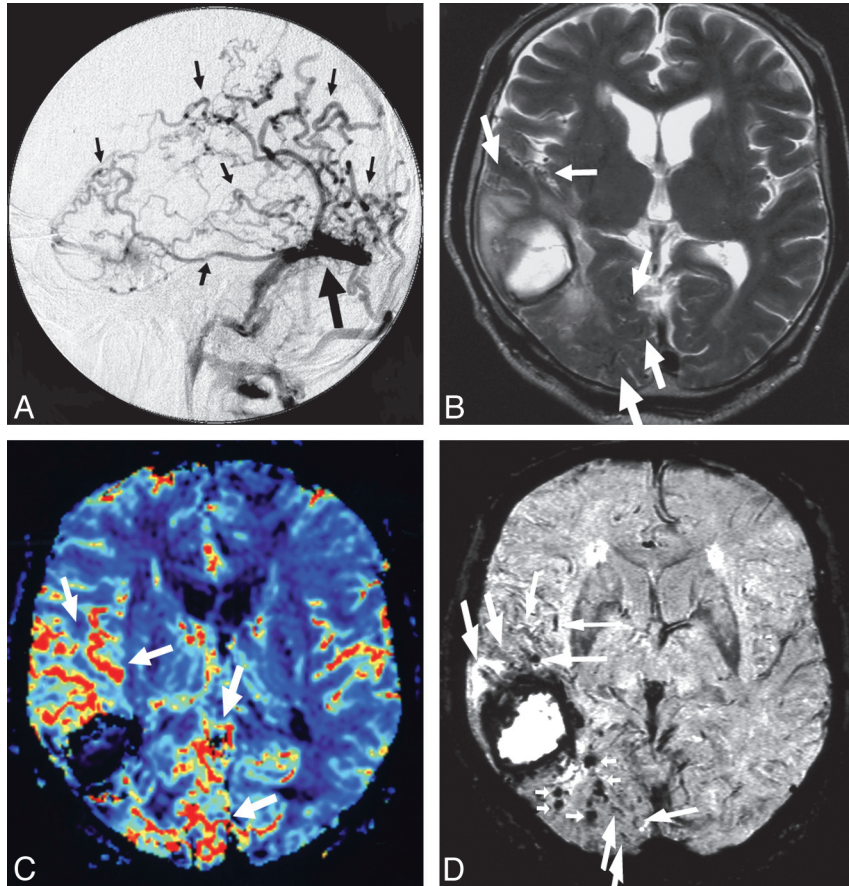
DAVF at the right TSS with the right hemisphere affected in a 67-year-old man (case 9). *A*, Arterial phase of a right external carotid angiogram shows a DAVF at the right TSS (*large arrow*) with RCVD in the right hemisphere (*small arrows*). *B*, T2-weighted image shows a subcortical hematoma in the right temporal lobe and abnormal flow voids around the hematoma in the right temporo-occipital region (*arrows*). *C*, DSC shows increased cerebral blood volume around the hematoma in the right temporal and occipital lobes (*arrows*). *D*, SWI shows dilation of cerebral veins (*large arrows*) and large and small hemorrhages (*small arrows*) in the right temporo-occipital region. Although it is difficult to definitively discriminate dilated venous structures and small hematomas by using SWI alone, the combination of DSC and SWI overcomes this limitation.
